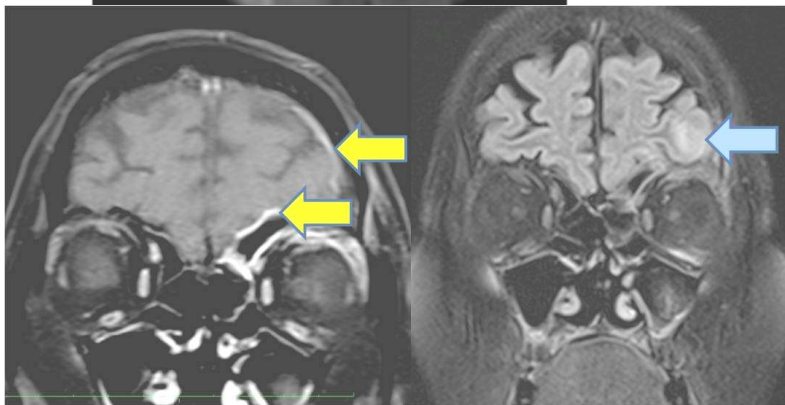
a/b: Meningeal and cerebral involvement: T1W +Gd coronal image show left frontal skull base and lateral frontal leptomenigeal enhancement (yellow arrow); FLAIR image show focal edema (cerebritis) at left frontal
